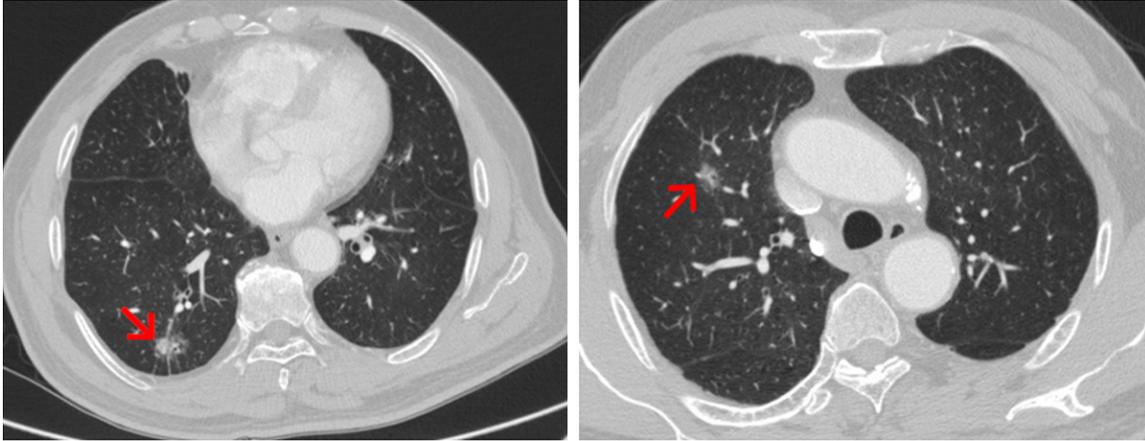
Chest CT showing a case of synchronous multiple primary lung cancer (SMPLC) manifested with two different ground-glass opacity (GGO) tumors at the upper and the lower lobes of the right lung, respectively.
